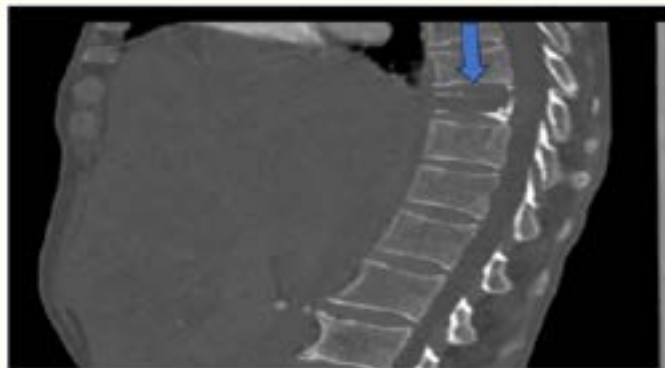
Sagittal reformatted CT scan of the dorsal spine demonstrating a severe compression fracture of the D9 (Blue arrow).
